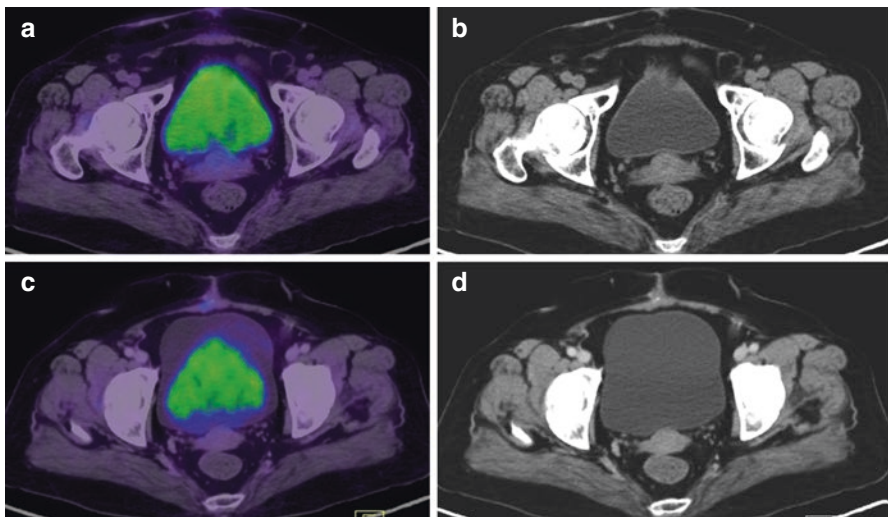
Bladder misregistration—fused PET/CT (a) images and corresponding section of plain CT (b) used for fusion. Contrast-enhanced CT was acquired after plain CT without changing the patient position. Misregistered PET/CECT image (c) and corresponding section of contrast-enhanced CT (d) used for fusion
